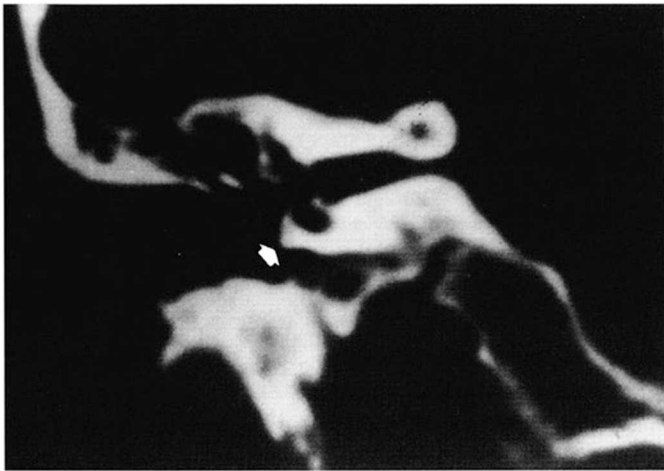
Coronal CT image showing osteoma emerging on the promontory.
